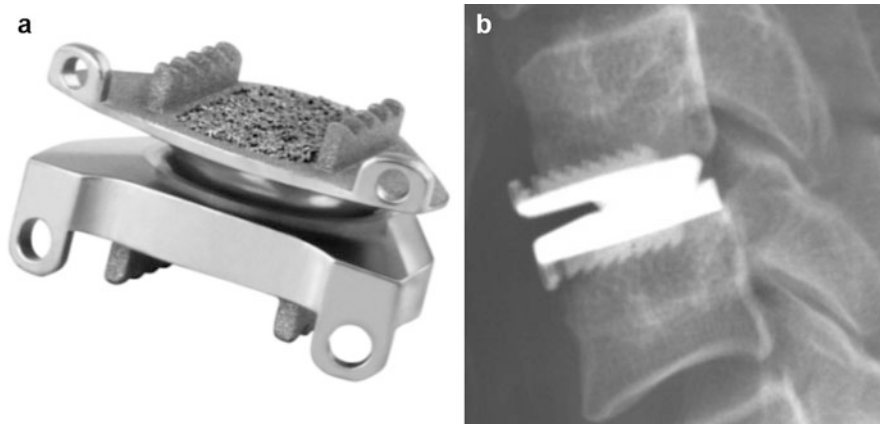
Prestige LP cervical disc: (a) device; (b) lateral X-ray after implantation
